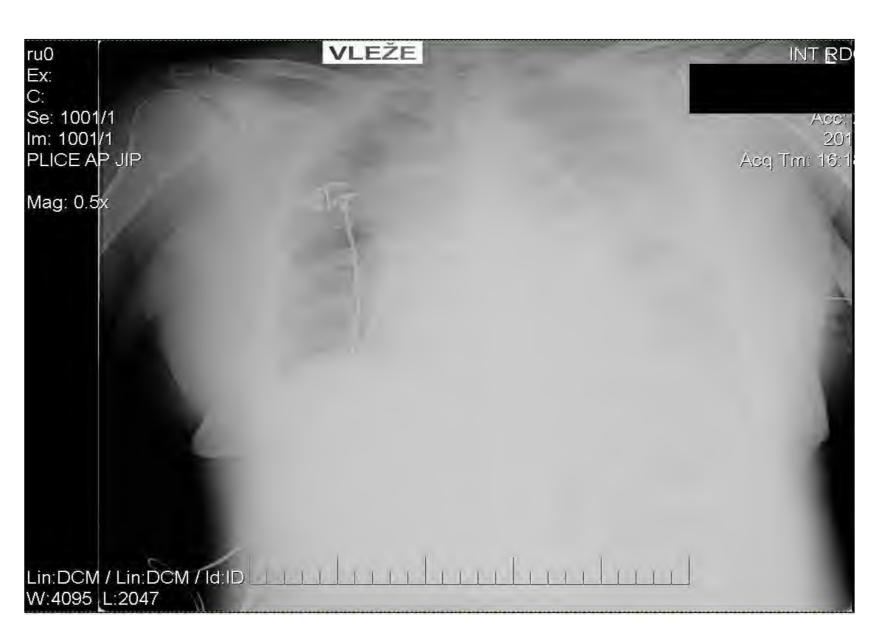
Chest X-ray, horizontal position
